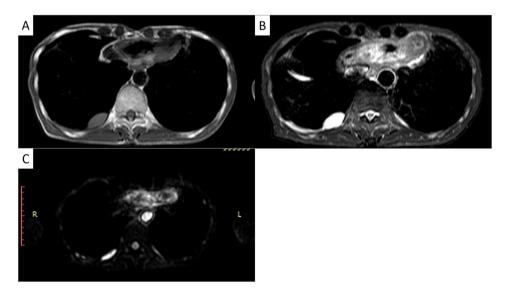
Contrast-enhanced chest magnetic resonance imaging. A: slightly high intensity on T1WI, B: high intensity on STIR, C: high intensity on DWI.
